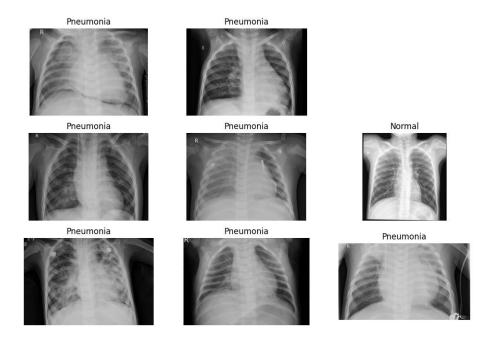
X-rays of both the classes(Normal, Pneumonia)
